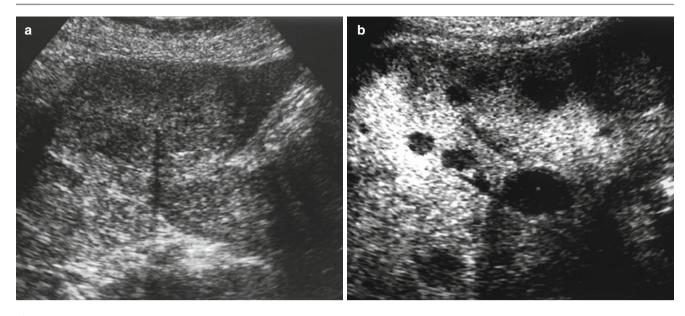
A 78-year-old man with metastatic liver disease. (a) Native B-mode sonogram shows inhomogeneous parenchyma of the liver, suggestive of focal liver lesions. (b) Contrast-enhanced late-phase pulse-inversion sonogram shows clear demarcation of multiple focal lesions
